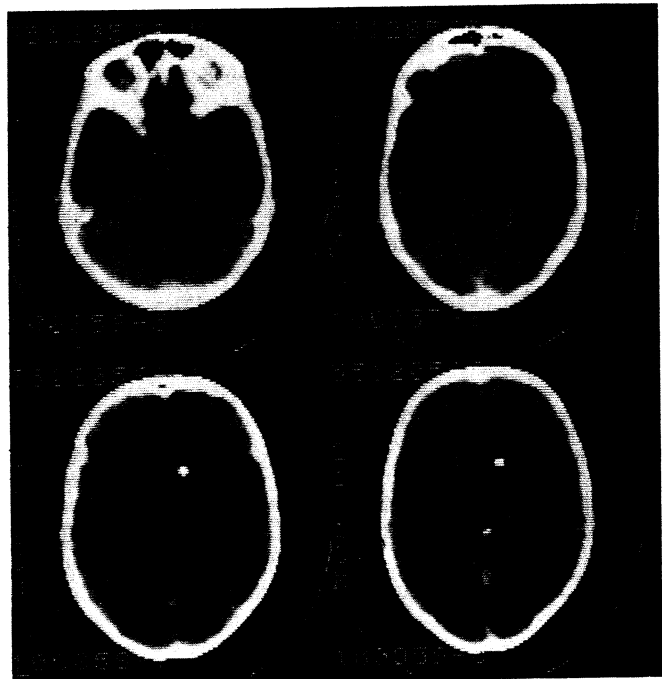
Case 1, post-irradiation CT scan with enhancement. All the enhancing lesions are gone. A mild widening of the ventricles is still present and the tip of a ventricular catheter is seen in the right frontal horn.
